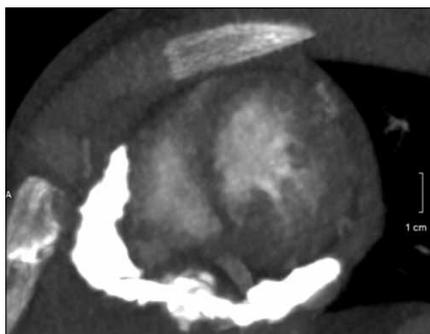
Sagittal contrast-enhanced thoracic computed tomography scan showing severe concentric pericardial calcification with partial infiltration of the myocardial free wall of the right ventricle with a maximum width of 10 mm
